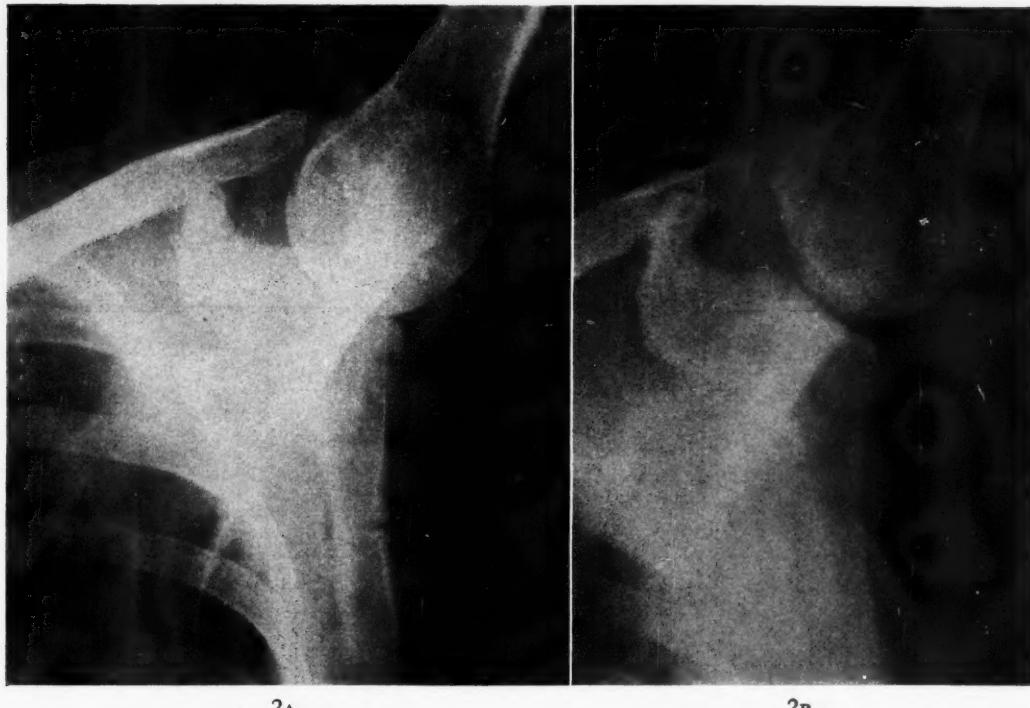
Case III. X-rays of the left scapula show the presence of a pseudofracture (A) in October, 1947, and its disappearance (B) in May, 1949, nineteen months following the institution of treatment.
